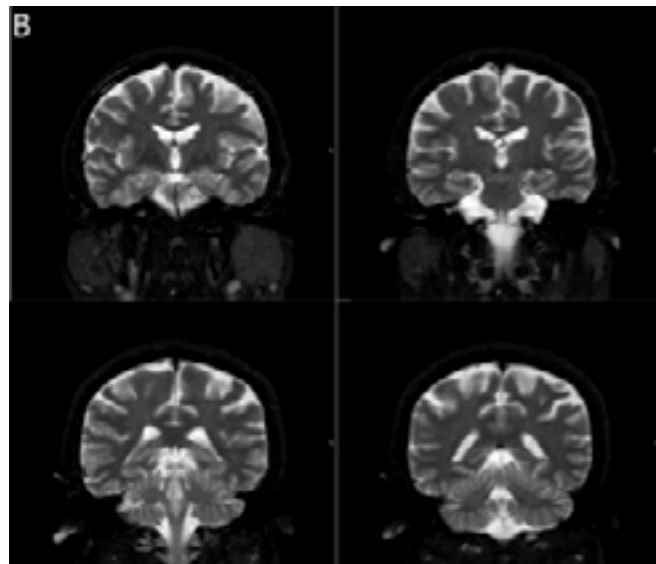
MRI shows left temporal atrophy
